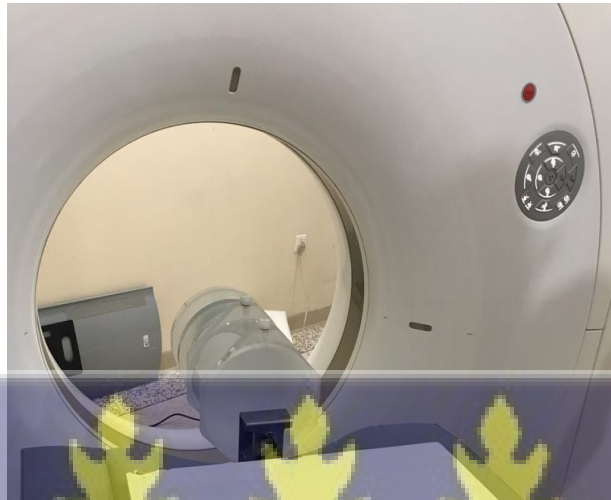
Setup for the determination of air and water CT numbers.
